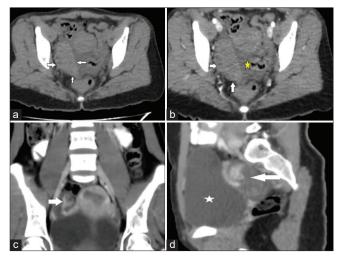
Computed tomography images of pelvis. (a) Noncontrast axial computed tomography (CT) image of the pelvis reveals enlarged, (6 cm × 3.5 cm) right ovary in the right adnexa with multiple small peripherally placed follicles (white arrows), (b) contrast-enhanced CT (CECT) axial image shows enhancing enlarged right ovary with multiple peripheral follicles (white arrows). Free fluid seen (yellow asterisk), (c and d) CECT coronal image, and sagittal images showing twisted right ovarian pedicle - "whirlpool sign" (white arrows). Distended urinary bladder (white star)
